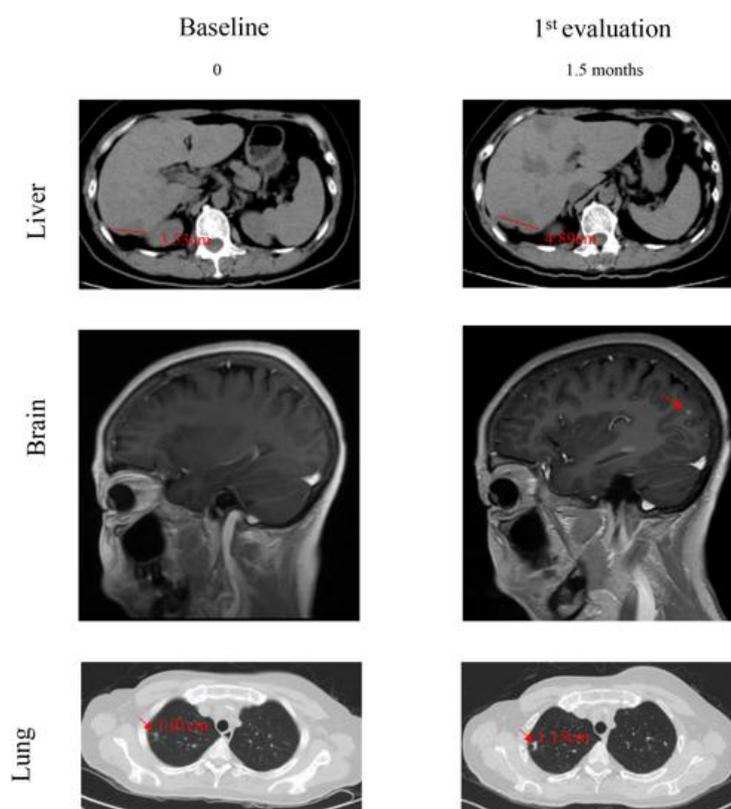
Tumor size before and after TQB2103 treatment. MRI scans and CT scans were performed 1 month before starting TQB2103 (column 1), at progression of new metastatic site in brain and increased site in liver (MRI scans and CT scans 1.5 months after starting TQB2103, column 2).
